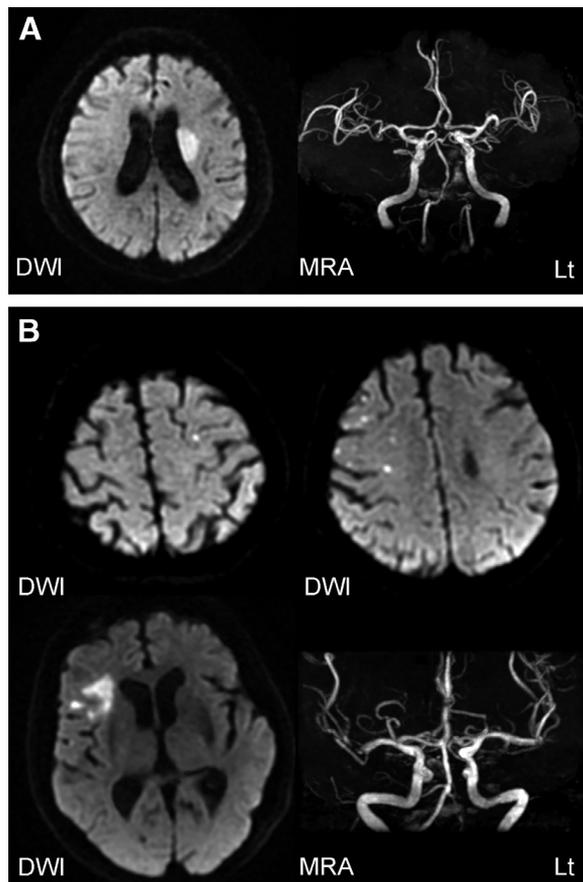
Representative brain images of patients with post-TAVI cerebral infarction. Case 2 (A): Diffusion weighted images (DWI) of MR scans showed acute infarction in the left corona radiata, while MR angiography (MRA) showed no stenosis/occlusion in the left middle cerebral artery (MCA), indicating reperfusion of embolus stagnated in the M1 part of the left MCA. Case 5 (B): DWI showed multiple acute infarctions in the right middle cerebral artery area, and a tiny lesion in the left cortex. MRA revealed no stenosis/occlusion in intracranial arteries. Abbreviations: Lt, left; TAVI, transcatheter aortic valve implantation.
